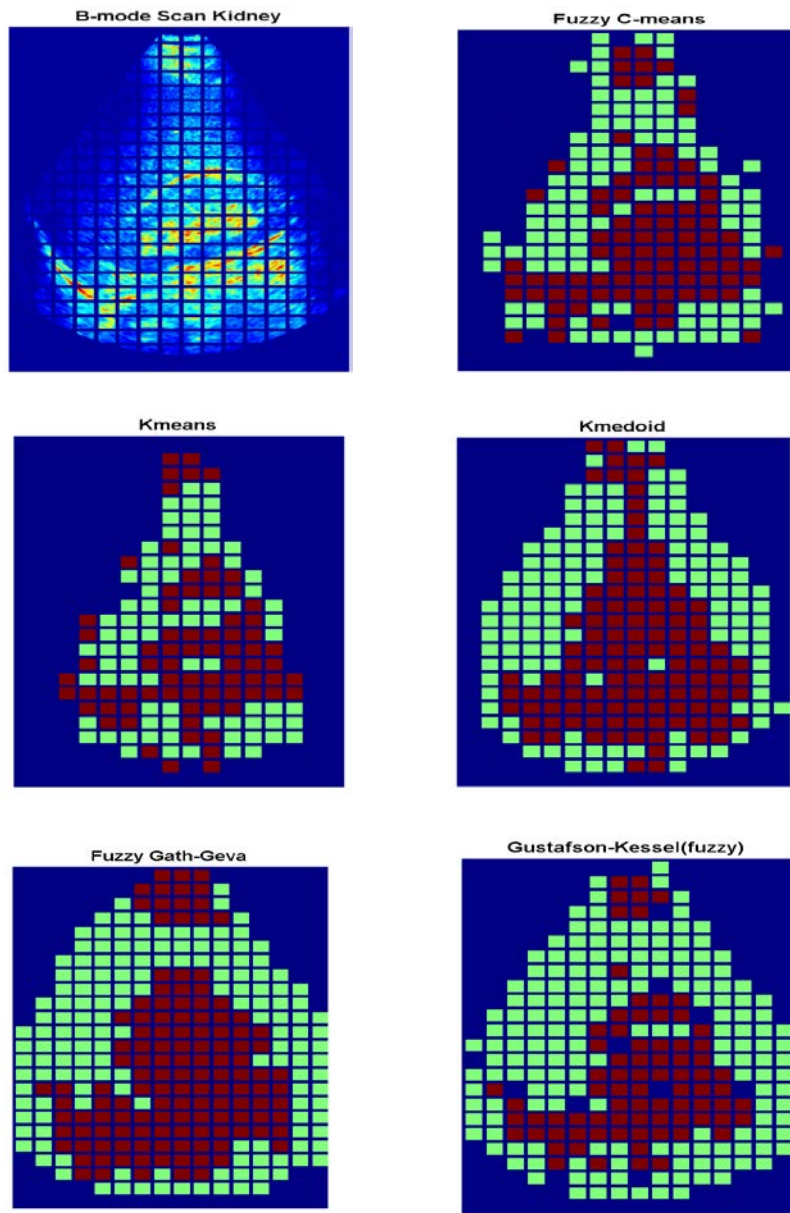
Results for recursive speckle tracking, fully automatic ultrasound image of the kidney (Sagittal).
